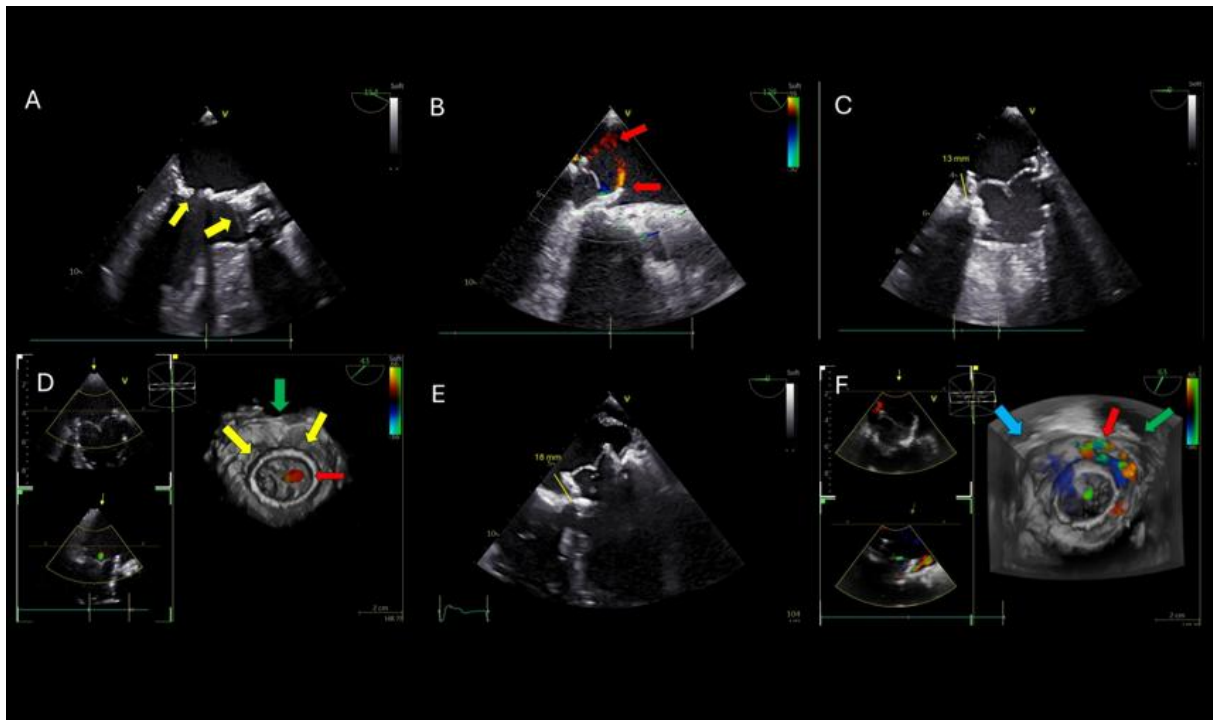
A. Pre-procedural transesophageal long — axis view demonstrating a degenerated surgical aortic bioprosthesis and heavily calcified mitral valve in complex multivalvular setting. Yellow arrows indicate the degenerated surgical aortic bioprosthesis and heavily calcified mitral valve. B. Post-procedural transesophageal long-axis color Doppler view after combined valve-in-valve transcatheter aortic valve implantation and transcatheter mitral valve implantation demonstrating a small paravalvular leak adjacent to the mitral prosthesis. Red arrow indicates paravalvular leak adjacent to the mitral bioprosthesis. C. Post-procedural modified mid-esophageal view demonstrating the initial position and baseline left atrial protrusion height of the mitral prosthesis. The line segment indicates baseline left atrial protrusion height. D. Three-dimensional *en face* transesophageal view demonstrating elliptic deformation of the mitral prosthetic frame with mild central regurgitation following resolution of the initial paravalvular leak. Yellow arrows indicate elliptic deformation of the prosthetic frame, the green arrow indicates the aortic root, and the red arrow indicates mild central regurgitation. E. Follow-up modified mid-esophageal transesophageal view demonstrating atrial displacement of the mitral prosthesis with a 5 mm increase in left atrial protrusion height compared with baseline. The line segment indicates the measured increase in left atrial protrusion height at follow up. F. Three-dimensional *en face* transesophageal view demonstrating crescentic paravalvular regurgitation accompanied by mild central regurgitation at follow-up. The blue arrow indicates the left atrial appendage, the green arrow indicates the aortic root and the red arrow indicates the paravalvular regurgitation, while the central color Doppler signal represents mild central regurgitation
